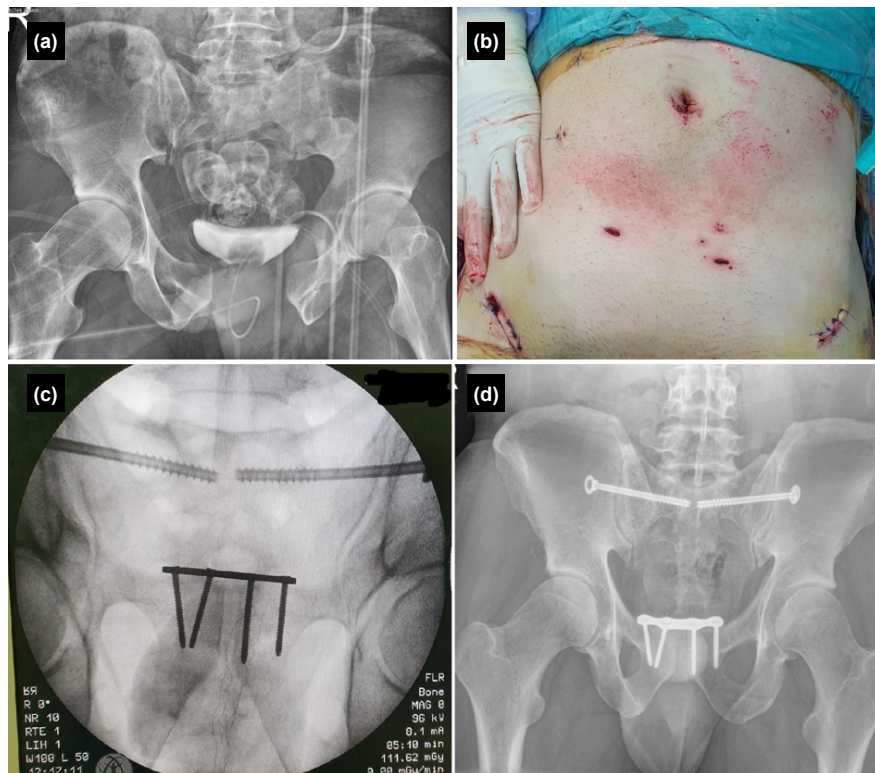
(a) Preoperative pelvis AP radiograph of a patient with an APC3 pelvic ring injury (Young-Burgess classification) and a C1-2D injury (AO/OTA classification); (b) Incisions used during the surgery; (c) Fluoroscopic check after the surgical procedure; (d) Postoperative 16th-month pelvis AP radiograph of the patient.
